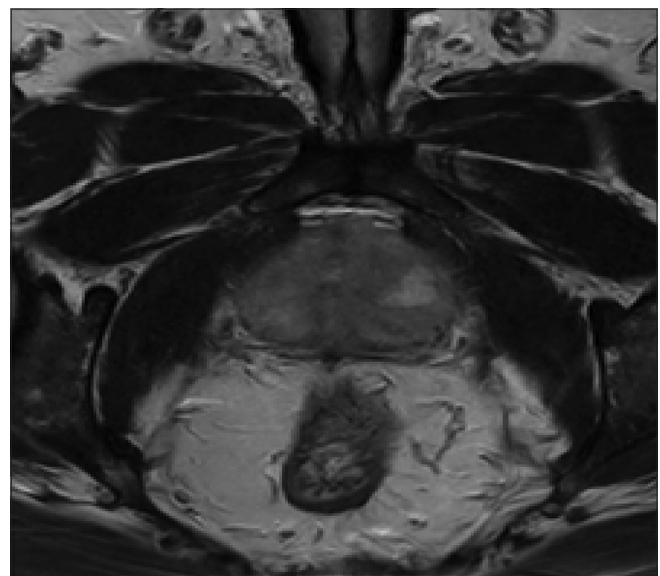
Magnetic resonance imaging of the prostate. Focal areas of restricted diffusion with larger appearing bright on T2-weighted images are seen involving the prostate gland extending from the apex to the base predominantly on the left side. They show peripheral enhancement on postcontrast imaging and represent areas of abscess formation
